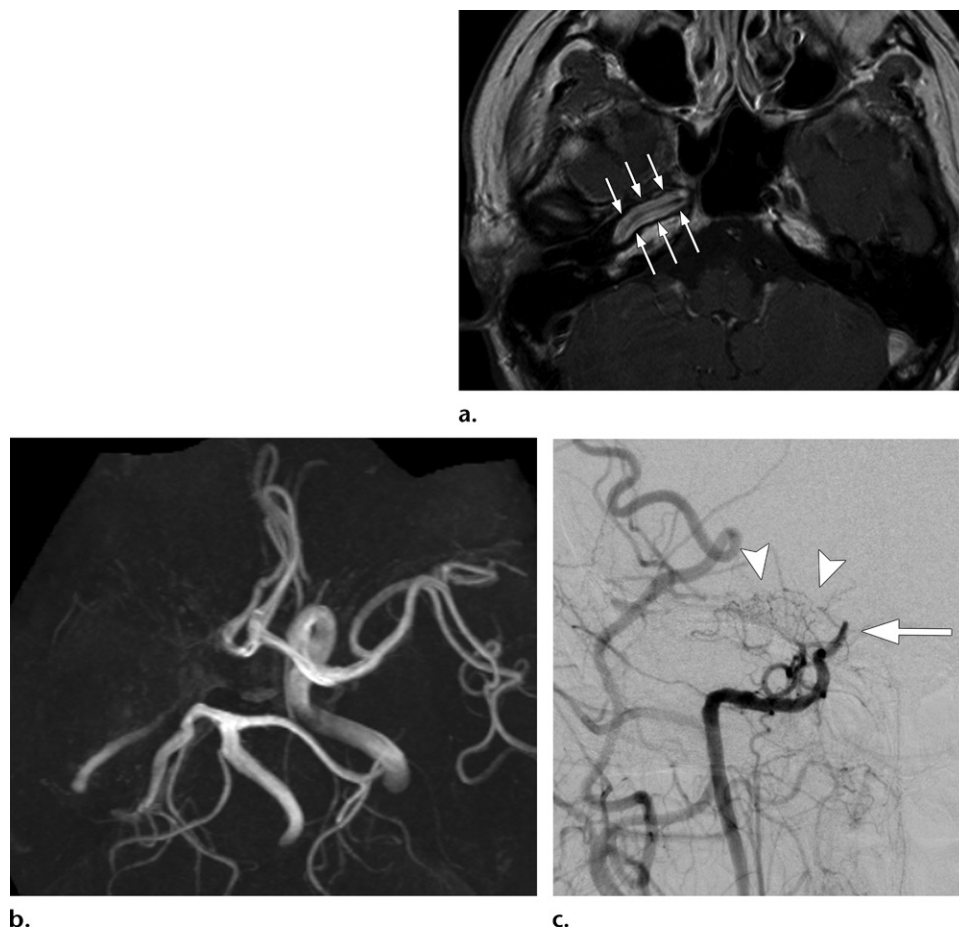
Steno-occlusive vasculopathy in a 47-year-old woman with a history of stereotactic radiosurgery for an arteriovenous malformation in the right temporal lobe. (a) Axial contrast-enhanced T1-weighted image shows wall thickening and enhancement of the skull base right internal carotid artery (ICA) (arrows). (b) Maximum intensity projection from time-of-flight MR angiography shows the steno-occlusive state of the right distal ICA. (c) Frontal projection from digital subtraction angiography of the right ICA shows the steno-occlusive state of the right distal ICA (arrow) and the development of lenticulostriate collaterals at the skull base (arrowheads).
